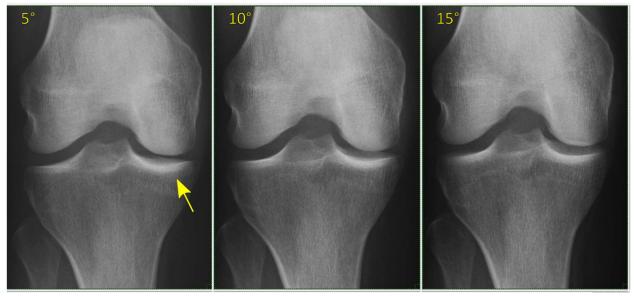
Example of knee radiographs at 5, 10, & 15 degree beam angles, where the 5 degree beam angle radiograph is acceptable.
